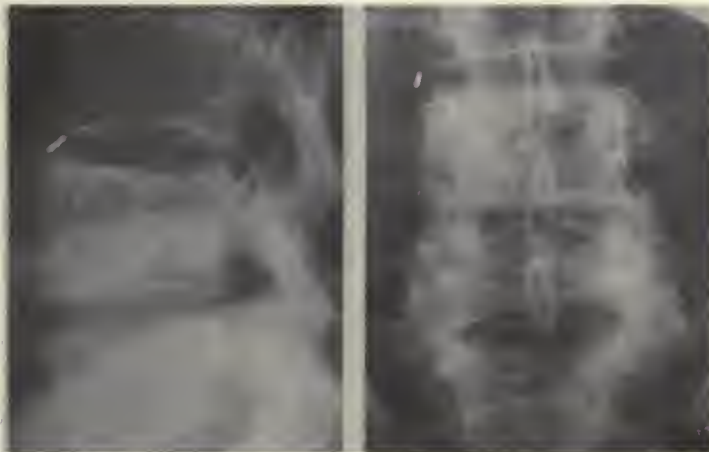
Healed chordoma. The radiograph was made two years after treatment. The tumor has been arrested for five years as of September 1957.
